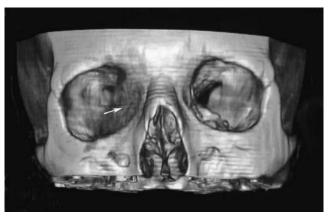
A three-dimensional reconstruction of a computed radiographic tomogram reveals the position of a metastatic adenocarcinoma in the medial portion of the right orbit (arrow).
